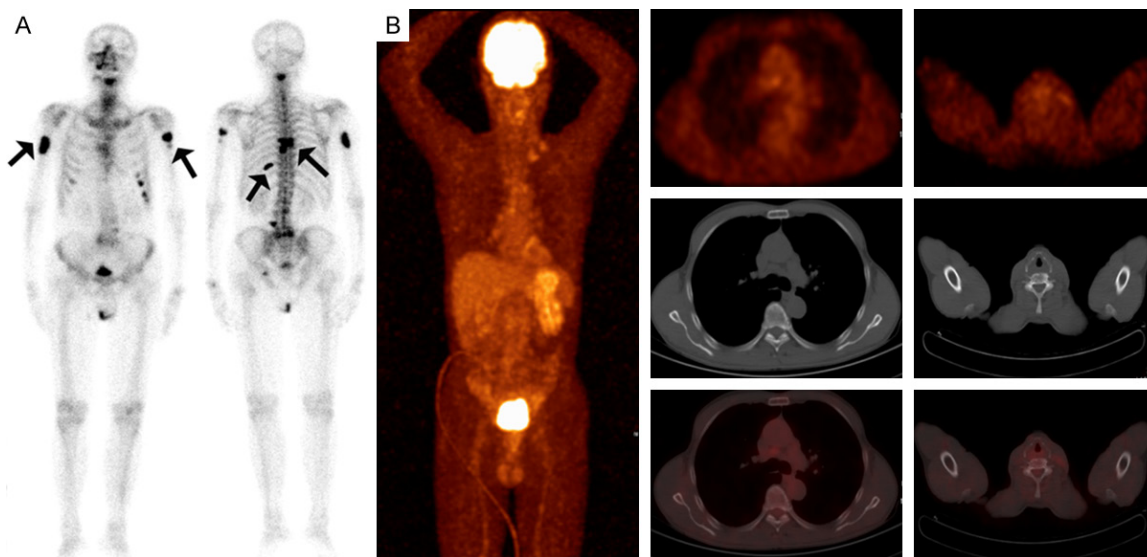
^{99m}Tc -MDP bone scan showed multiple intense uptake in the skull, multiple vertebral bodies and ribs, bilateral humerus, and left acetabulum, which indicated extensive bone metastasis from prostate cancer (A) while these lesions were not detected on PET/CT (B).
